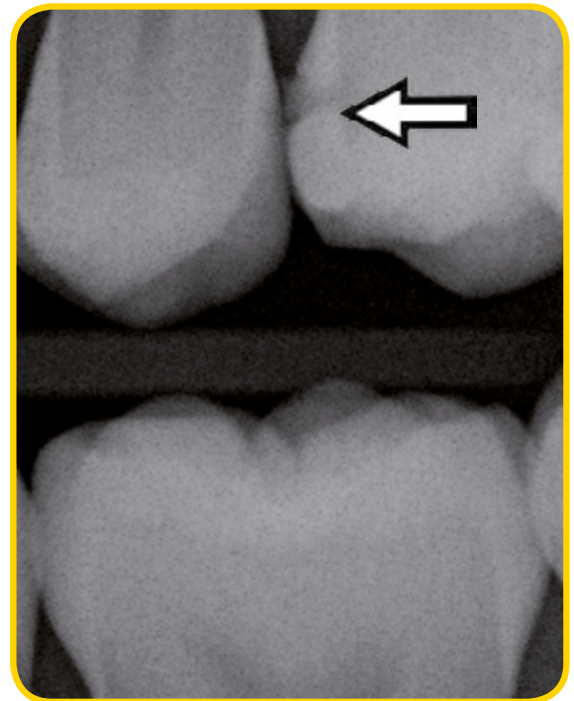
Digital x-ray image
